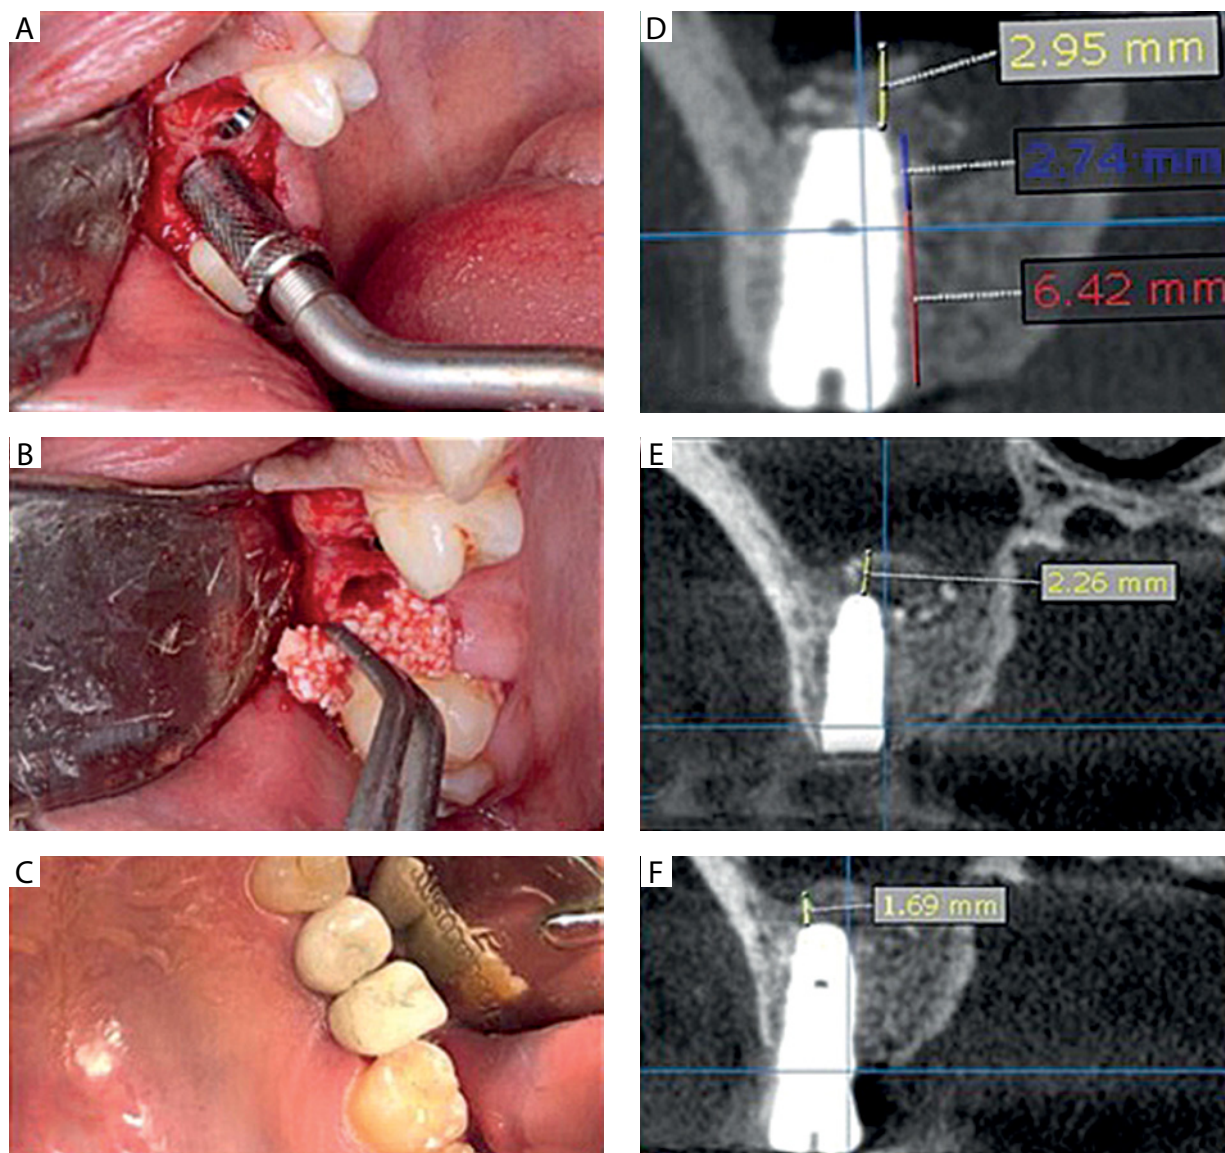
Osteotome application (A), sticky bone application (B), crown placement (C), post-operative CBCT (cross-sectional view) showing ■ graft apical height, ■ implant protrusion, and ■ residual bone height at T⁰ (D), GHa at T³ (E), and GHa at T⁹ (F)
